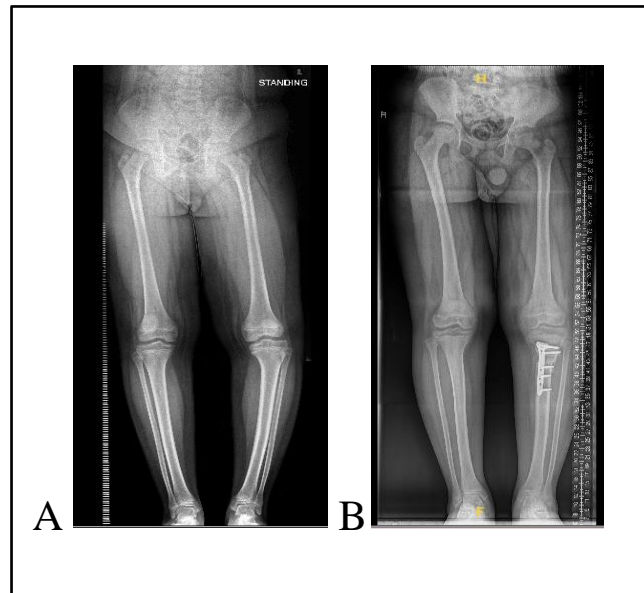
(A) Pre-operative radiograph. (B) Radiograph at 3 months post-operation showed corrected genu varus.
